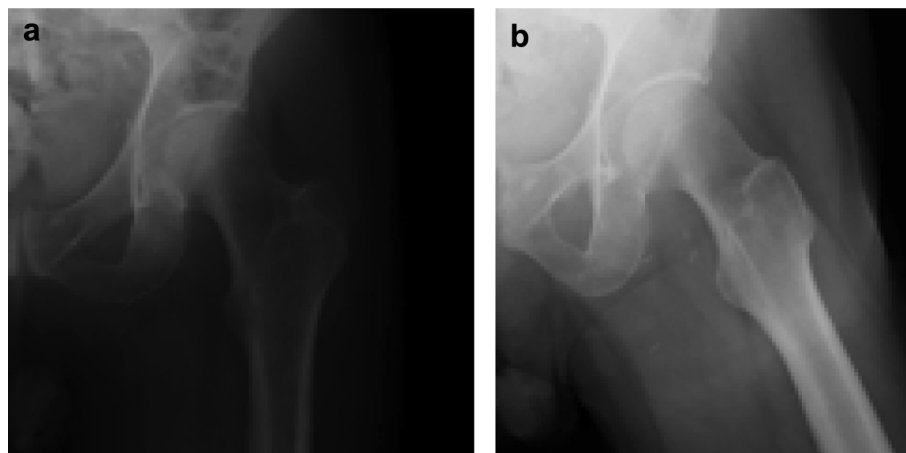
Initial anteroposterior (AP) radiograph of left hip (a) and lateral radiograph (b) showing no fracture or major bony lesion.
